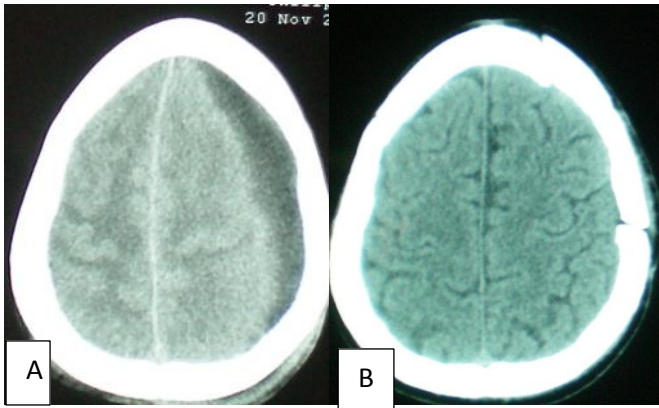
Preoperative (A) and postoperative (B) CT scan of left convexity subdural empyema
